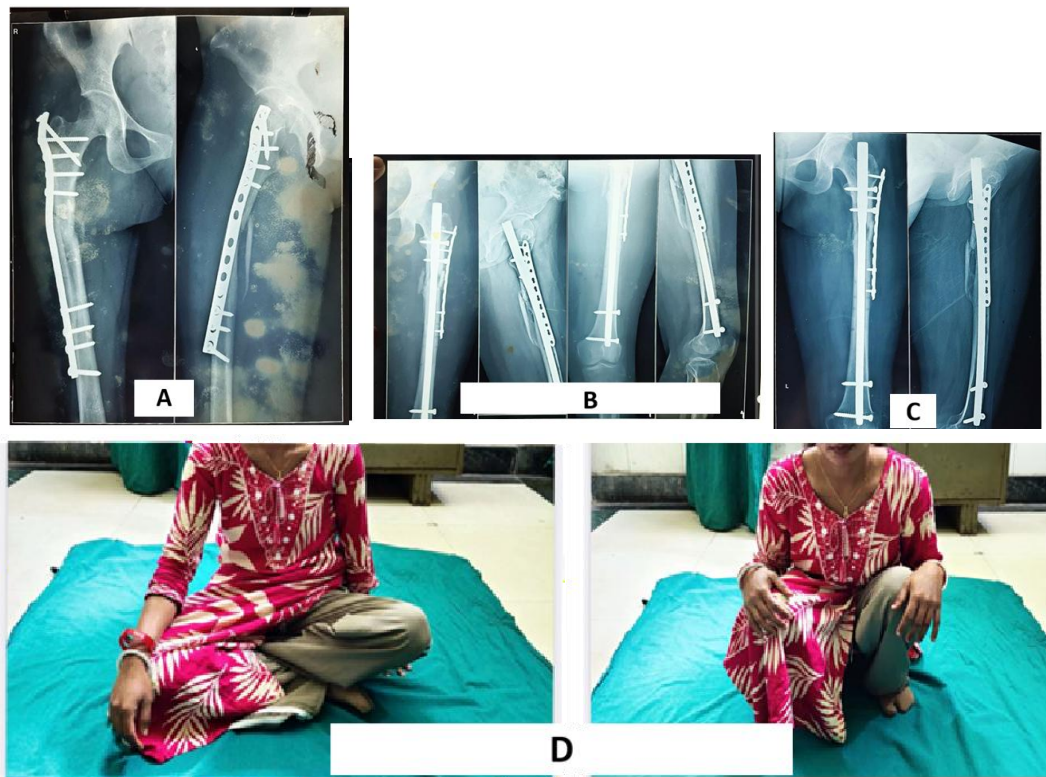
(A): Preoperative radiograph of a 29-year-old female presenting with a peri-implant fracture following index plating of a subtrochanteric femur fracture; (B and C): Radiographs at 1-month and 3-month follow-ups after revision surgery utilizing an intramedullary nail combined with a neutralisation plate and bone grafting; (D): clinical photographs demonstrating restored alignment, independent sitting, and hip flexion.
